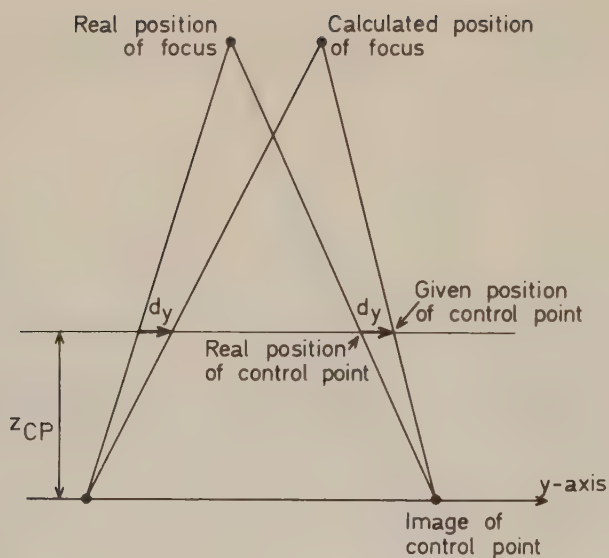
Demonstration of the influence of an error d_y of given CP coordinates on calculated position of the roentgen focus. The distance between the FM:s' and CP:s' planes is z_{CP} .
